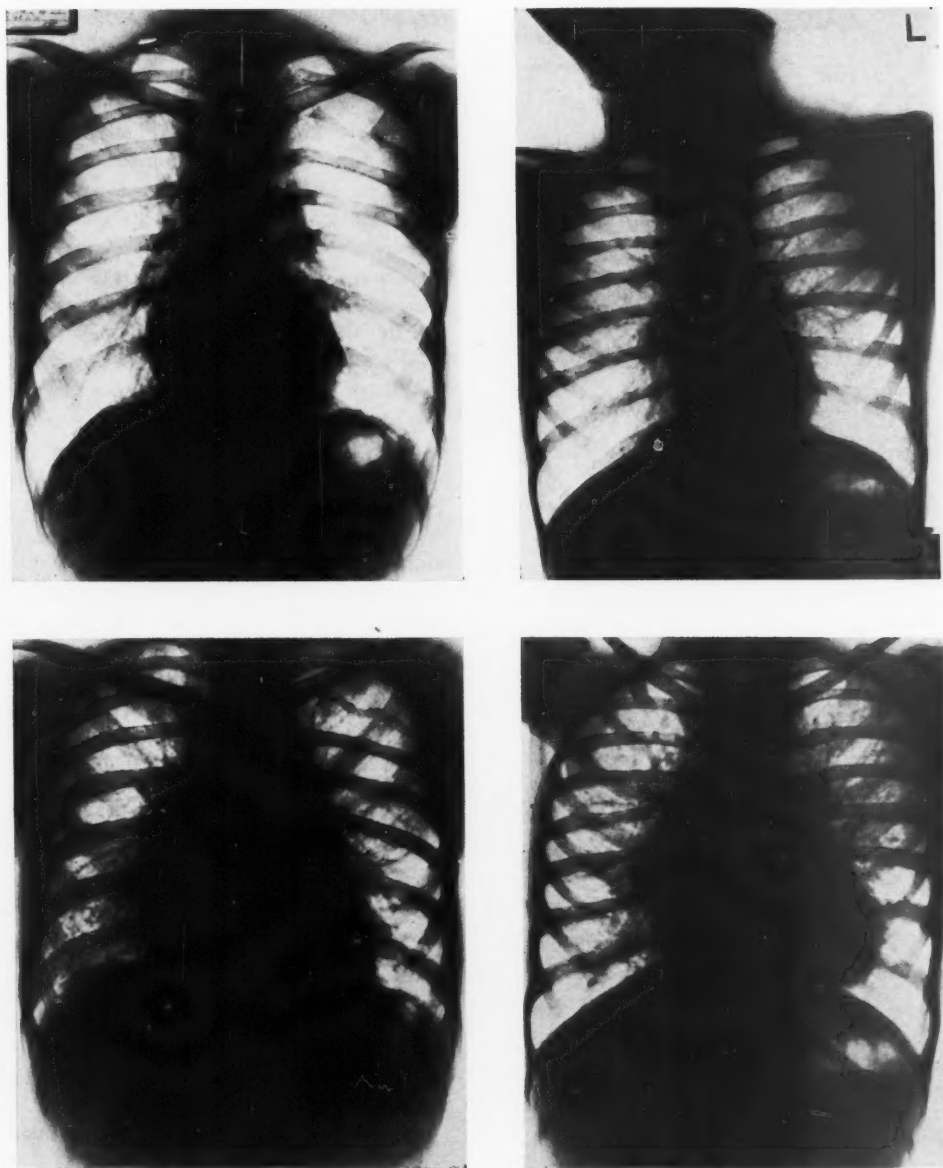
Chest x-rays before (*above*) and after (*below*) operation. The heart size has increased and pulmonary plethora has developed. *Left.* Male, L.S., age 26. Cardio-thoracic ratio before operation 48; 1 year later, 57. *Right.* Female, J.R., age 6. Cardio-thoracic ratio before operation 39; 9 months later, 58.
